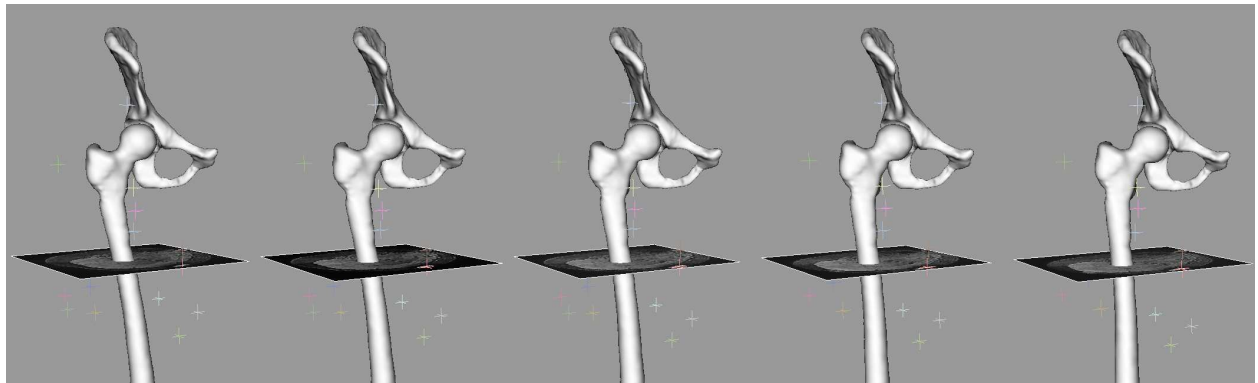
Landmark tracking in sequential MRI, during an abduction motion pattern
